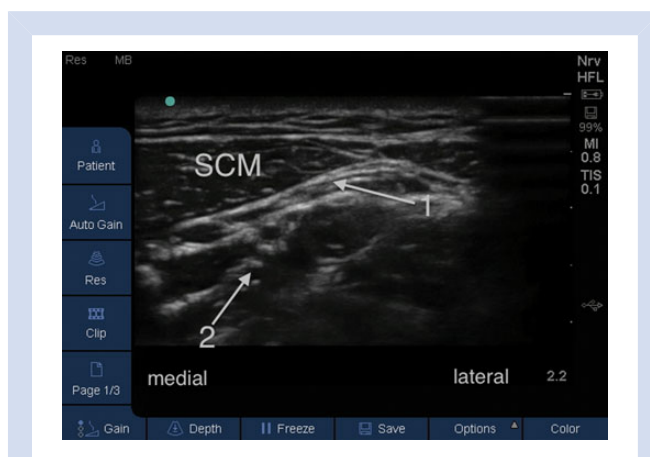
Ultrasound anatomy demonstrating the sternocleidomastoid muscle (SCM), interscalene groove between scalene muscles (arrow 2) and the superficial cervical plexus—hypoechoic nodules—under the lateral border of SCM (arrow 1). Moving the ultrasound probe medially, one would visualize the internal jugular vein and carotid artery.
